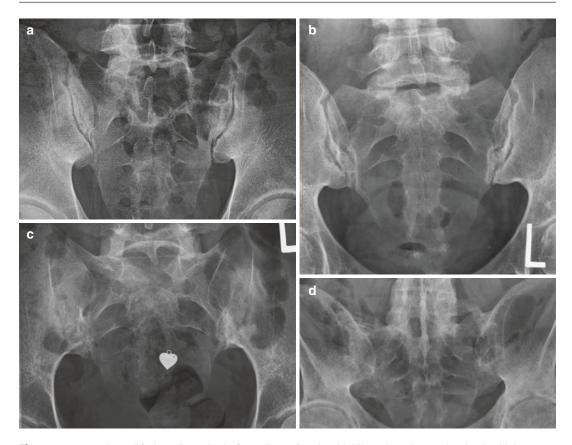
New York modified grading criteria for radiographic sacroiliitis, grade 0 (Fig. 6.2), (a) grade 1 with suspicious changes, possible early erosions of the inferior sacroiliac joints bilaterally, (b) grade 2 in a 36-year-old
